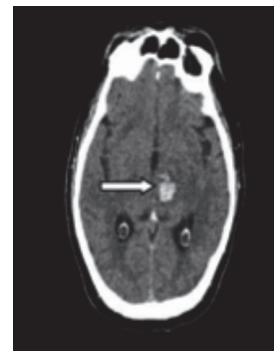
(A): Axial Plain CT Brain Image Showing Hyperdense Areas in the Left Thalamus
